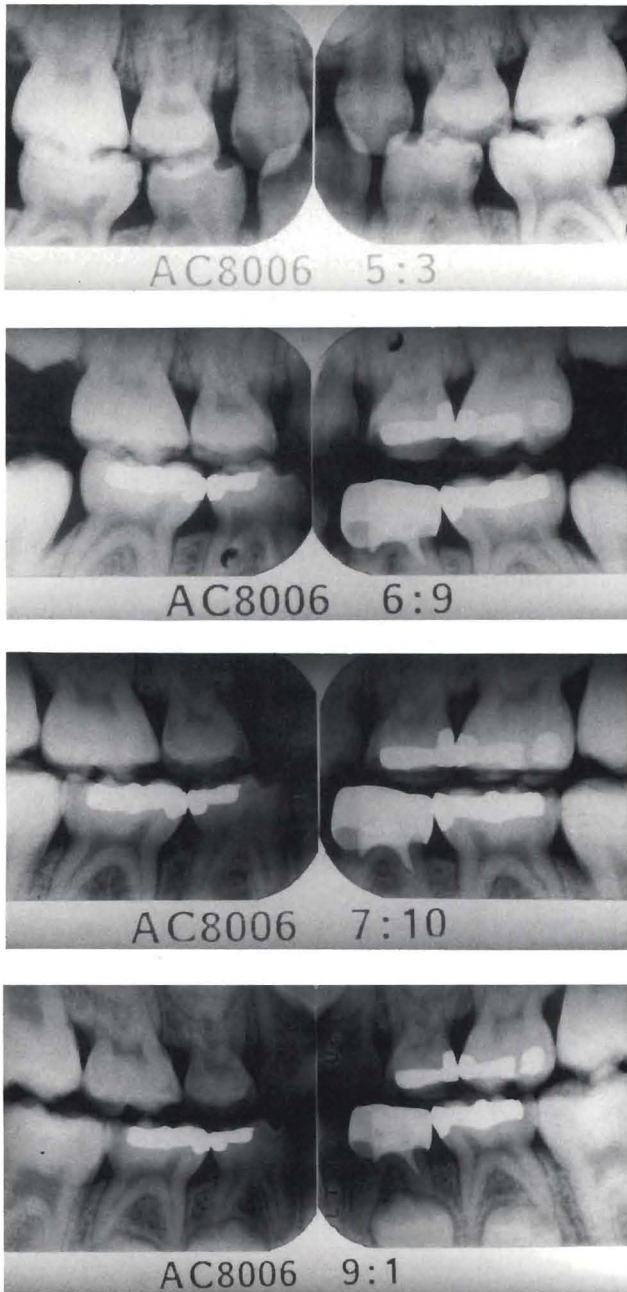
Representative bitewing series of patient where the electrourgically pulpotted tooth (#L) was "normal" at the last observation visit. The pulpotomy was performed at age 5 years, 3 months (a); and postoperative radiographs were taken at age 6 years, 9 months (b); 7 years, 10 months (c); and 9 years, 1 month (d).
